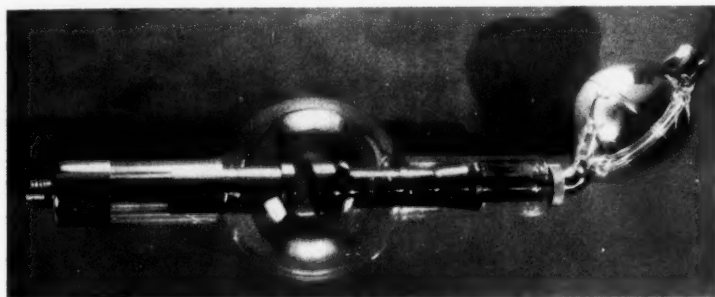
Highest power radiographic tube, rated 85 K.V.P., 1,000 ma., 1/30 second or 50 K.V.P., 500 ma., 1/2 second, and capable of handling 2,000 of these exposures in one 8-hour day.
